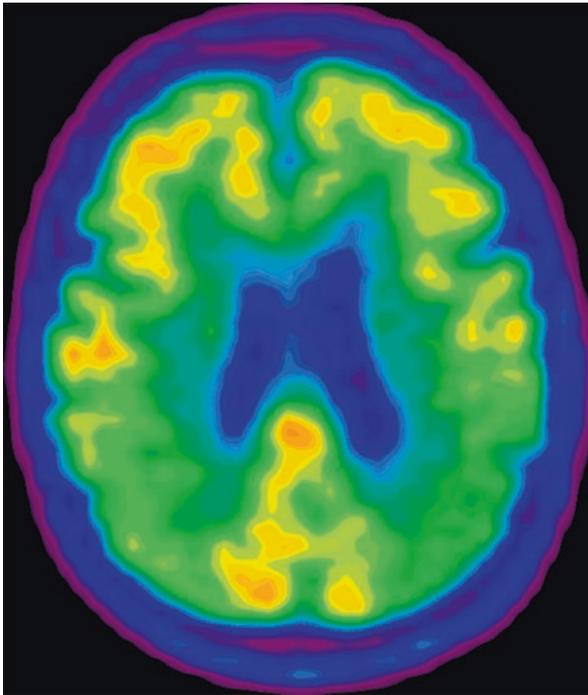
FDG-PET (*axial view*). Note presence of bilateral parieto-temporal hypometabolism characteristic of AD, worse on the left
